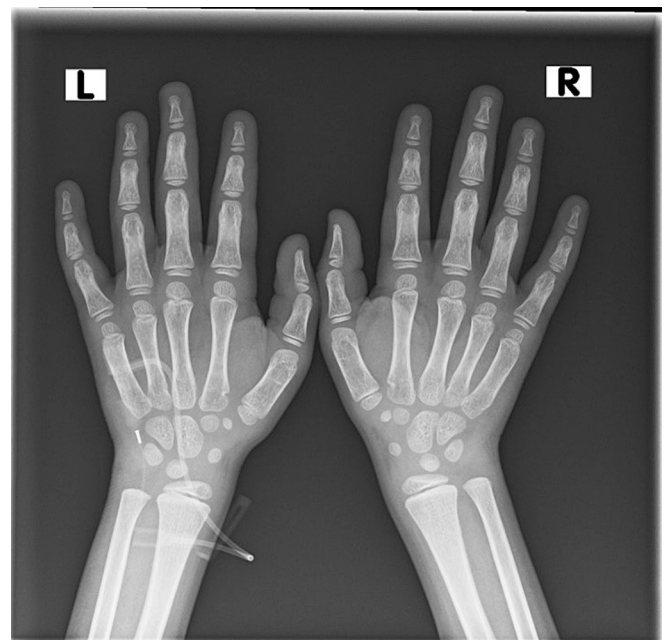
A Hand wrist radiograph to rule out subperiosteal resorption.
